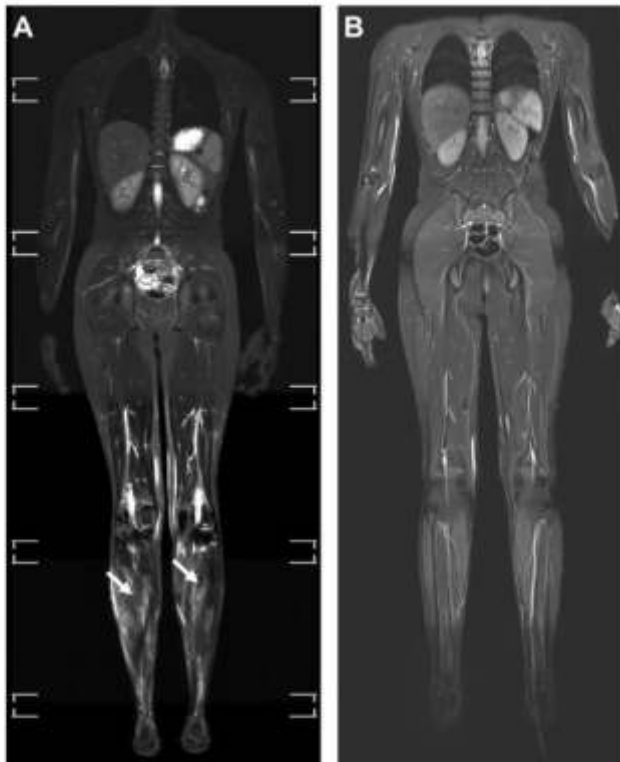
WB MRI of a 15-year-old girl with benign acute childhood myositis due to Influenza B showing diffuse muscle edema in the calves on the coronal STIR (Arrows) in A. WB-MRI performed as follow-up 1 month later demonstrating a complete resolution of the muscle edema (coronal STIR in B).
